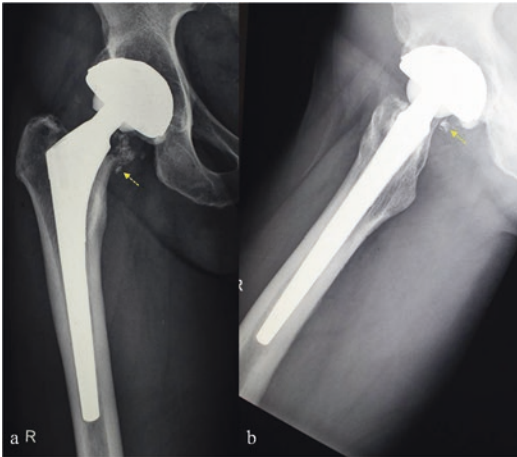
Anteroposterior (a) and axial (b) radiographs of the right hip demonstrating ceramic fragments embedded in the joint capsule
